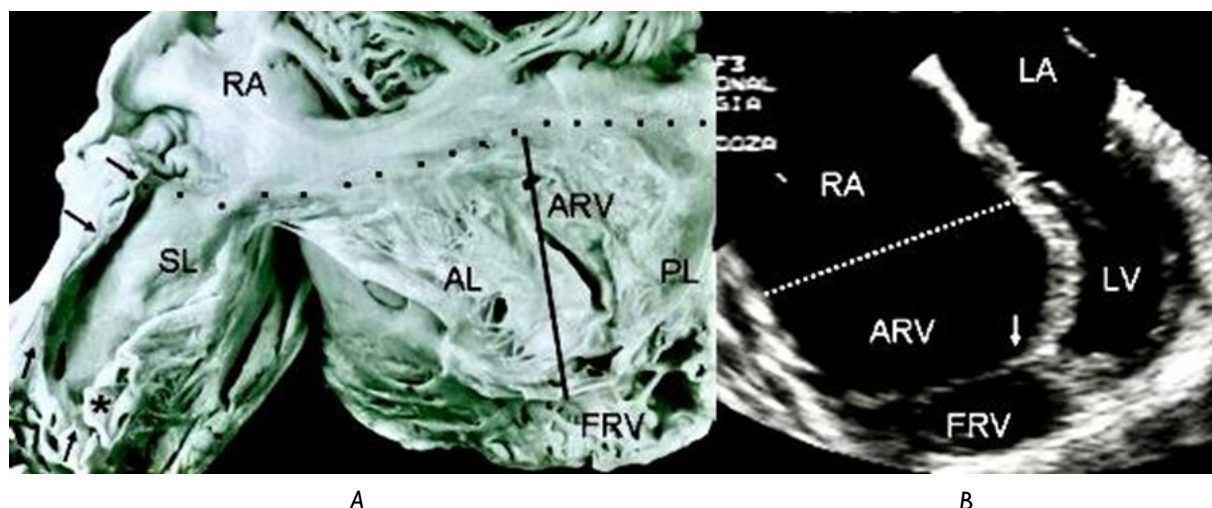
(a) Internal view of the right chambers of a heart shows grade III tethering of the tricuspid septal leaflet. The arrows point to tethering of the posterior leaflet. The flap of the free portion of the septal leaflet can be seen (asterisk) as well as the redundant anterior leaflet with 3 accessory openings. (b) The 4 chamber echocardiographic image shows the same features and the greater size of the atrialised portion of the right ventricle with significant reduction of the functional portion.
